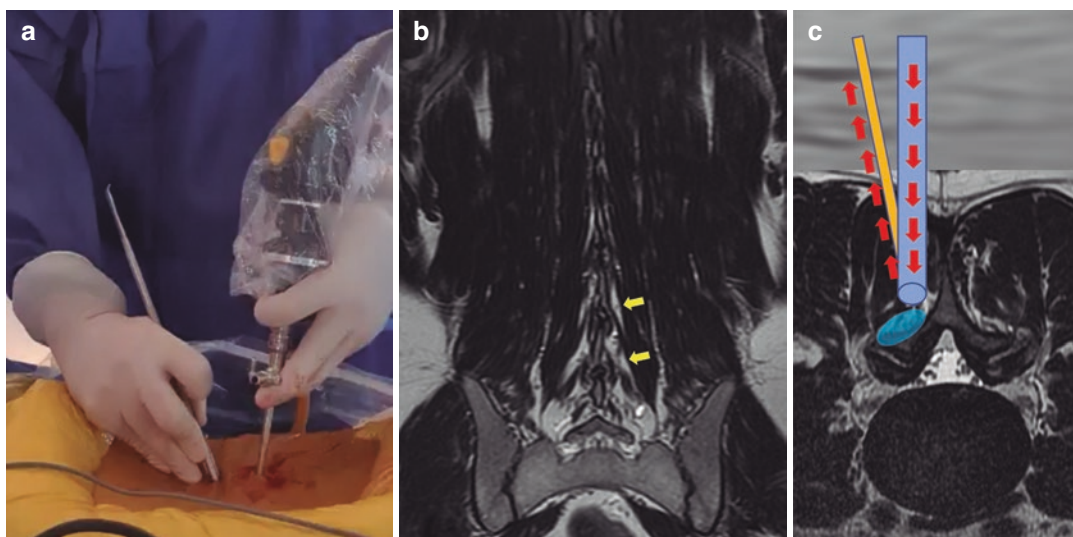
UBE procedure. (a) Two ports are created to introduce the endoscope and common spinal surgical instruments, with which the surgeon is familiar. (b) Coronal view of lumbar MRI. The yellow arrows are located in the multifidus muscles pointing toward a hyperintense triangular area known as the multifidus triangle, which corresponds to the epiperiosteal space. (c) Fluid
